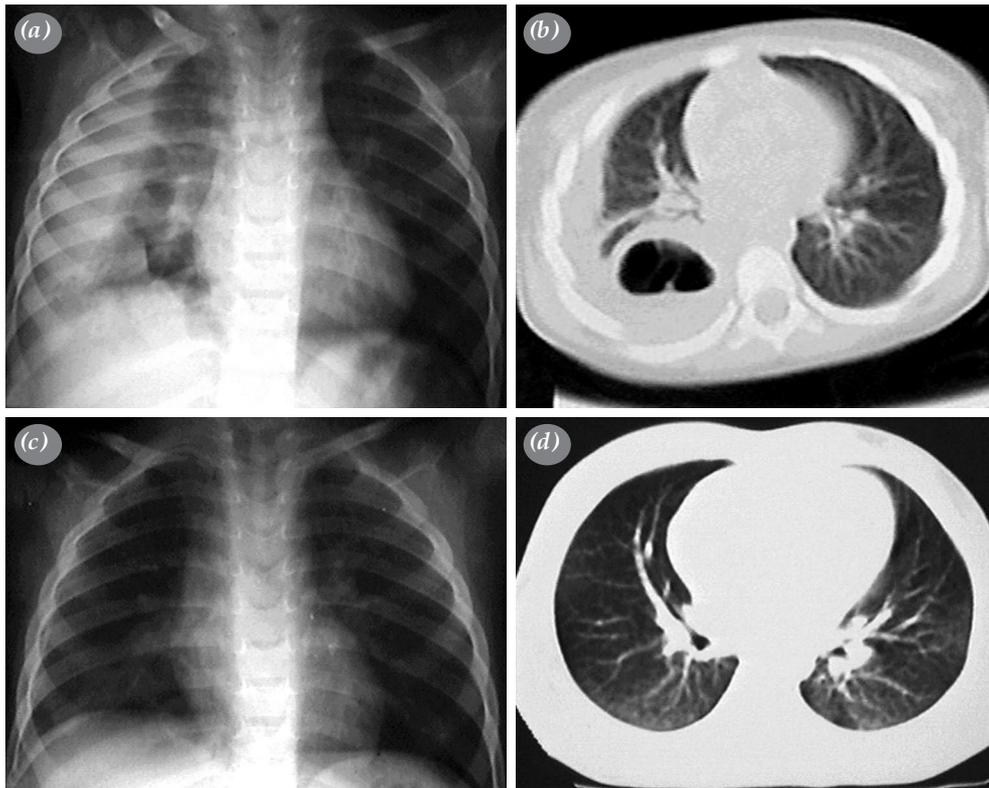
(a) Chest X-ray of a patient with empyema. (b) Thorax CT of a patient with empyema. (c) Chest X-ray after treatment. (d) Thorax CT after treatment.
